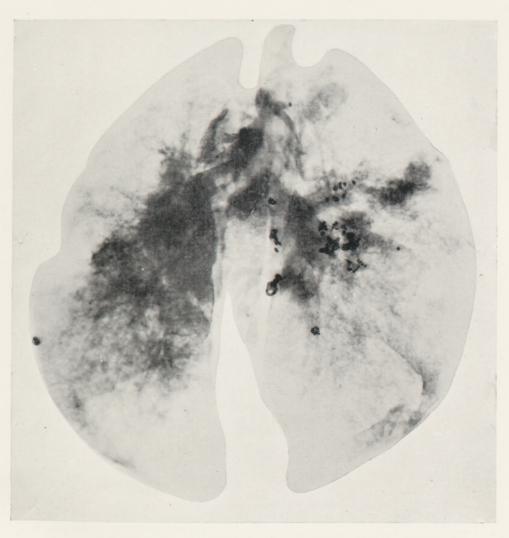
Radiograph. Case 564, Msutu, aet. forty-five with four years' service. Slight tuberculo-silicotic lesions in lungs and glands. A subpleural calcified scar in the left lower lobe, probably a primary affect, certainly not a tuberculo-silicotic patch. Calcification in several of the tuberculo-silicotic glands.
